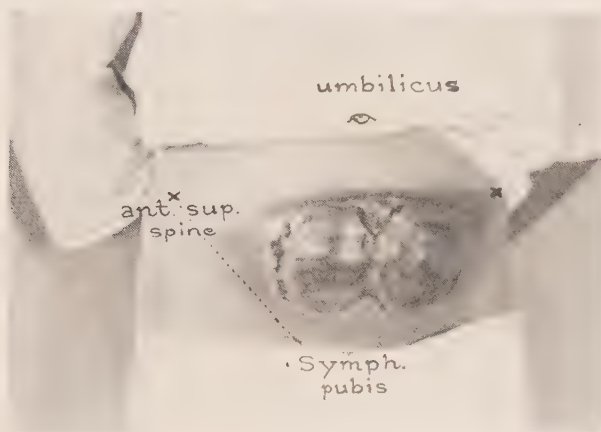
Necrosis of the entire thickness of the abdominal wall from the Roentgen treatment of a uterine fibroid. Secondary peritonitis and death. (Dr. C. H. Shearer.)
